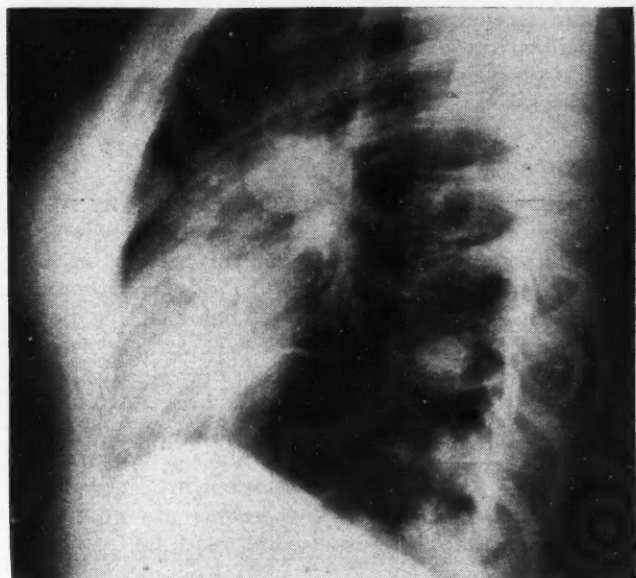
Chest roentgenogram (lateral view) taken March 23, 1953.
